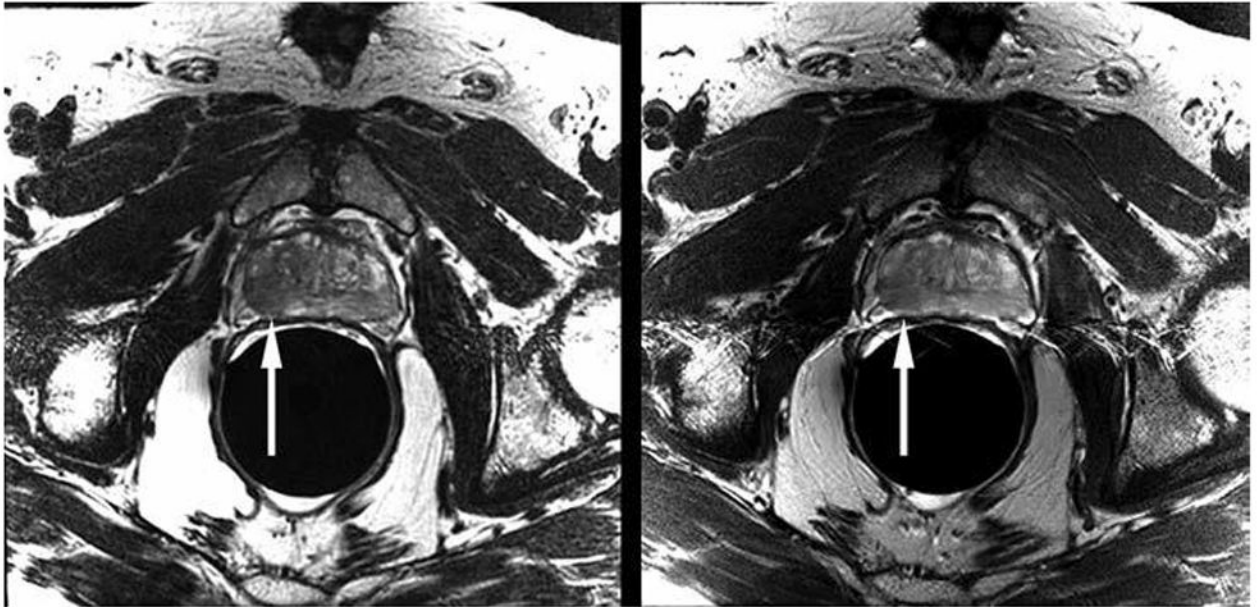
Example computerized slide shown to readers (PowerPoint for Mac 2011 [version 14.4.2], Microsoft) comprises axial T2-weighted 3D fast spin-echo (FSE) MR image (*left*) and corresponding 2D FSE image (*right*). This 68-year-old man had biopsy-proven prostate cancer in peripheral zone of right mid gland. Tumor is visible on both images as focal area of decreased signal intensity (*arrows* [not present on slides reviewed by readers]).
